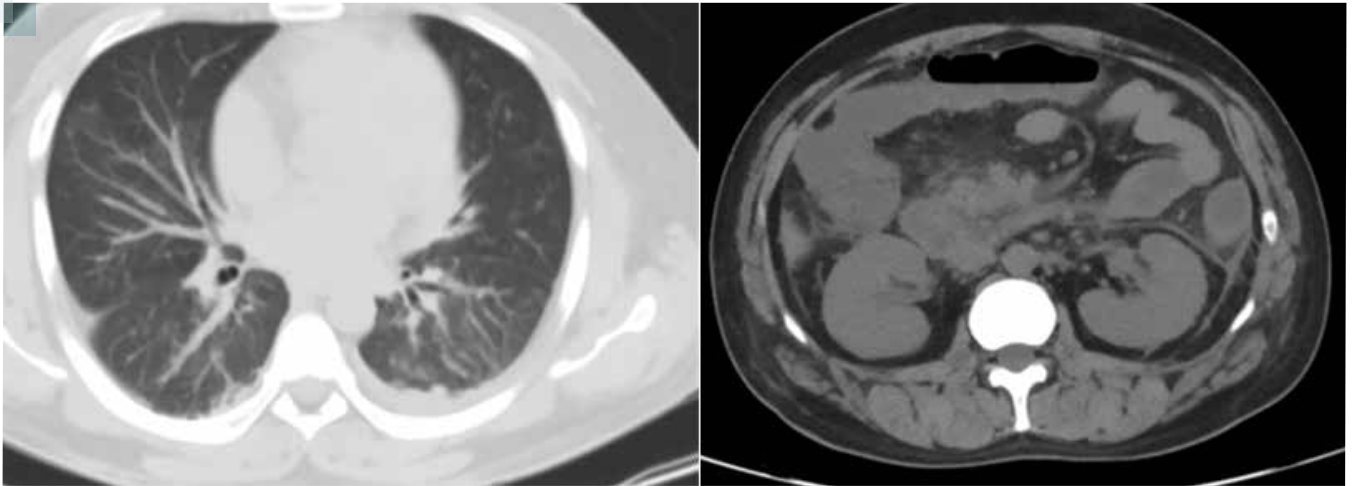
Non contrast CT scans chest and abdomen: left sided pleural effusion with multiple axillary lymph nodes, along with few subcentimetric mediastinal and abdominal lymph nodes, Hepatomegaly with mild bulky pancreas associated with peripancreatic fat stranding, mesenteric lymphadenopathy and moderate ascites.
